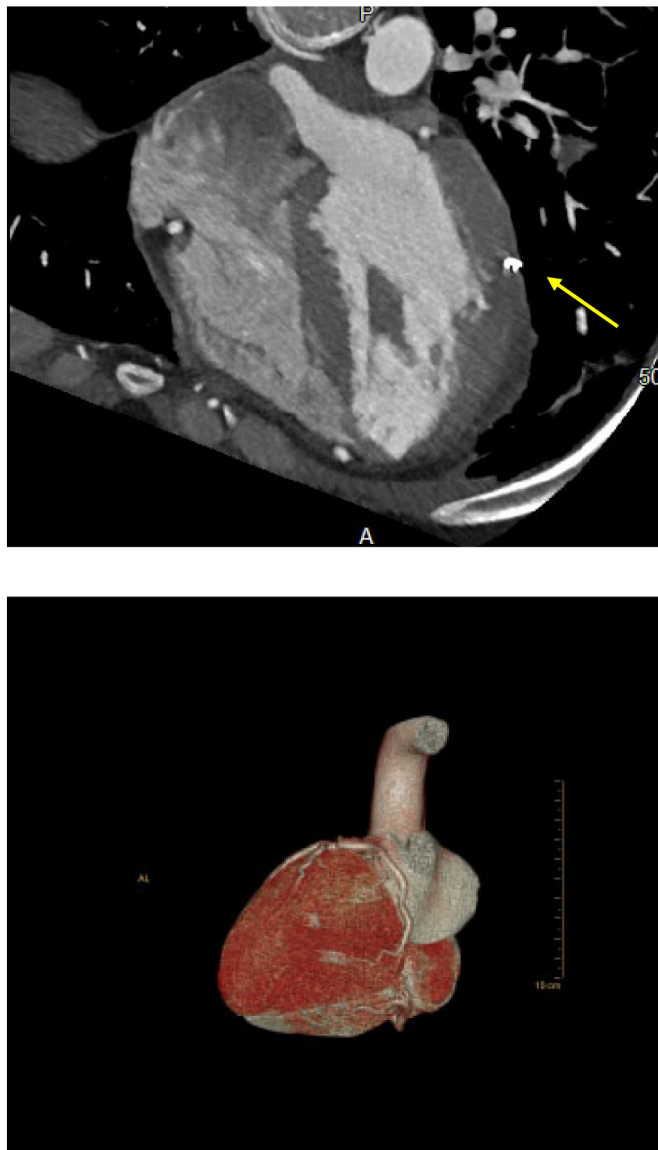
CT angio showing staples (arrow), no effusion, no aneurysm, and no mass effect from EVARREST patch.
